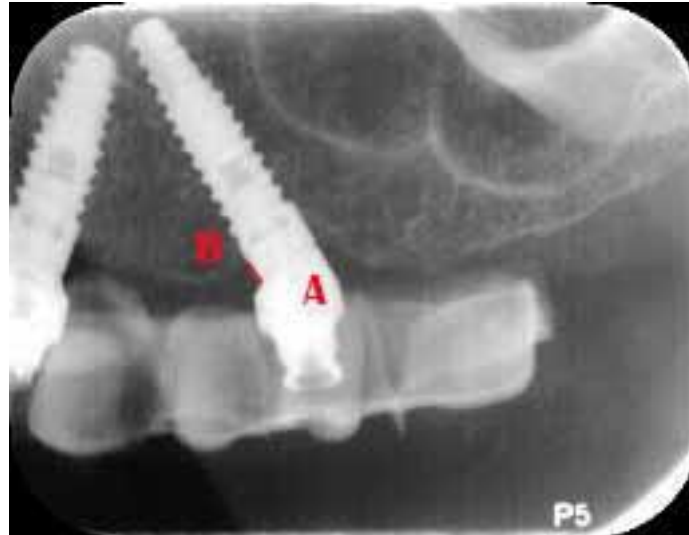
Periapical X-ray with reference lines and points
